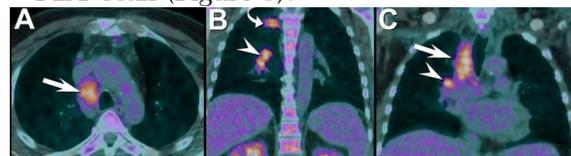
Axial (A) and coronal (B and C) FDG-PET images. Click [here](#) to open Figure 3 in a new, enlarged window.
